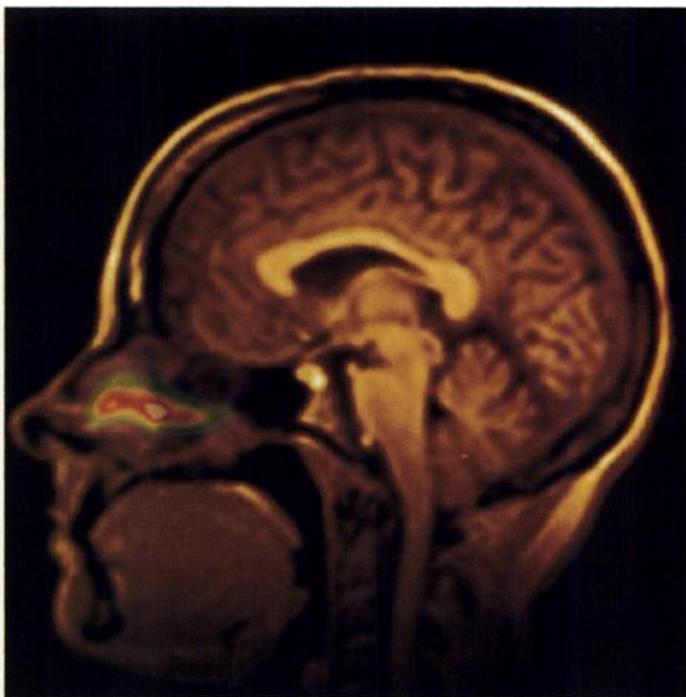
Display of PET data on MRI template, single sagittal slice through three-dimensional dataset, 8 mm from center plane of head. PET data are displayed with translucent rainbow color scale (blue as low counting rate to white as high counting rate), overlaid on MRI single-tone image.
